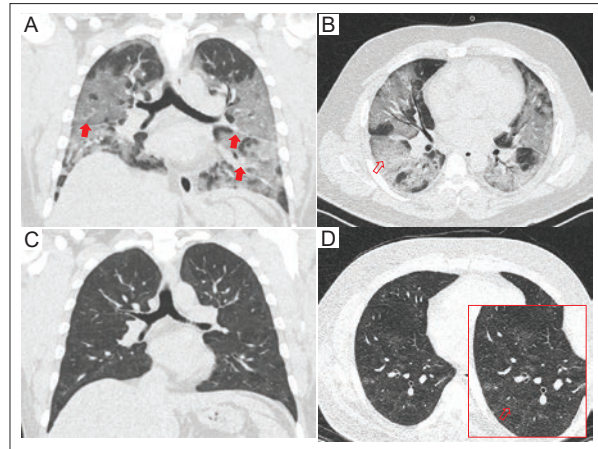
Chest CT of a 41-year-old male diagnosed with Long COVID. A: coronal and B: axial baseline images show pleural thickening in the fissures (solid arrows) and areas of interstitial impairment with ground-glass opacity in the lobules, predominantly in the peripheral and inferior segments with tendency for consolidation (open arrow). C: coronal and D: axial follow-up images taken 17 months after the initial infection, show focal and peripheral impairment with diffuse ground-glass areas, mainly in the periphery (zoomed image with open arrow). CT: computed tomography; COVID: coronavirus disease.
